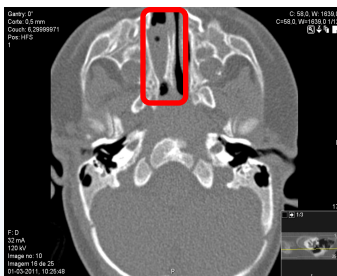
Axial computed tomography showing right mixed bony-membranous CA.
